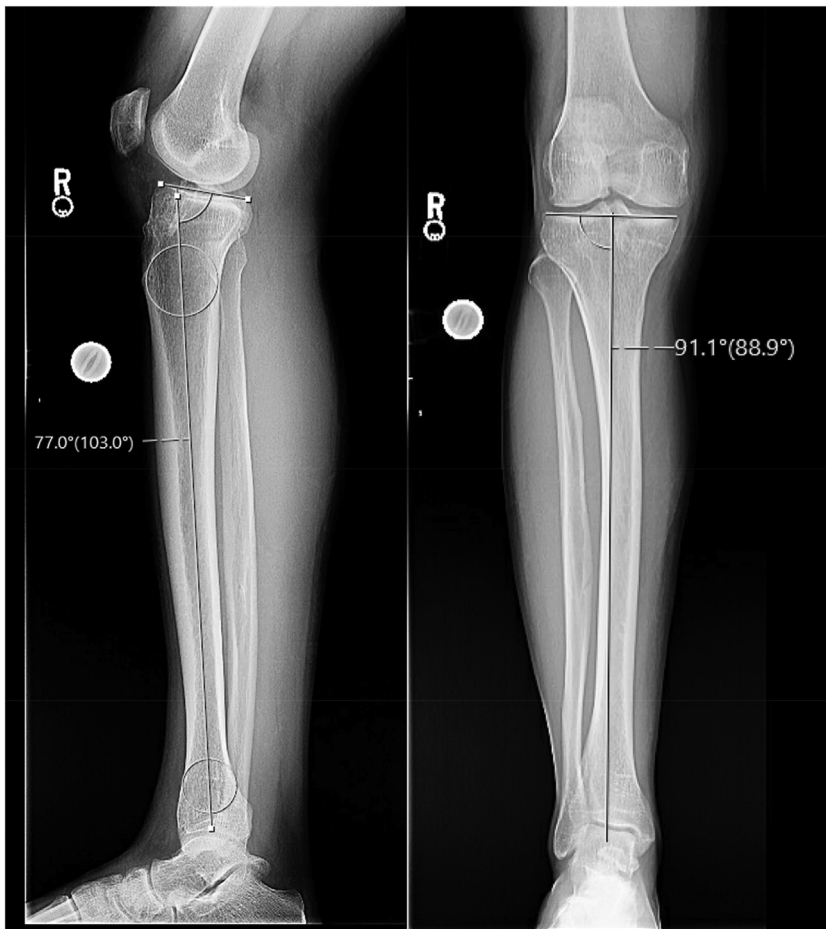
Anterior-posterior and lateral radiographs of the right knee and tibia demonstrating a case example of a 26-year-old man with 2 failed previous anterior cruciate ligament reconstruction reconstructions (first with bone–patellar tendon–bone autograft, followed by revision with hamstring allograft). Posterior tibial slope measures 13° on full-length lateral tibia radiographs (left), with minimal coronal plane malalignment on full length tibia anteroposterior radiographs (right).
